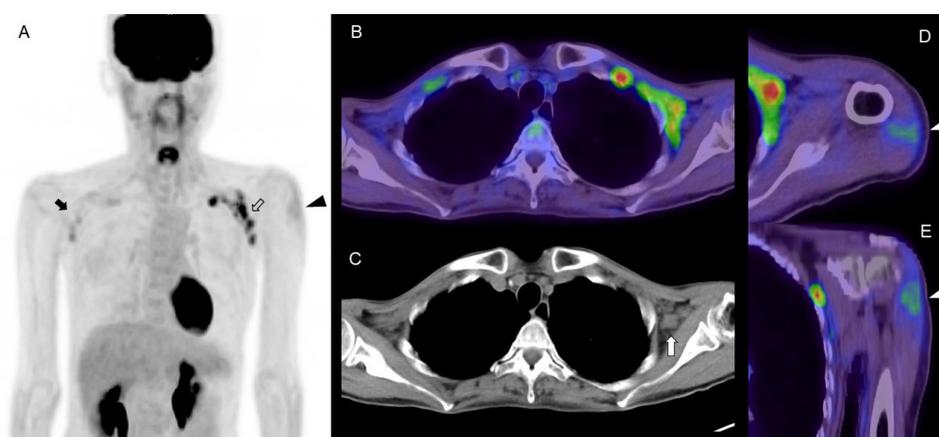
FDG PET/CT images in a woman in her 50s with abdominal malignancy at 4 days after COVID-19 vaccination. (A) MIP image, (B) axial fusion image, (C) CT image, (D) axial fusion image of deltoid muscle, (E) coronal fusion image of deltoid muscle. Increased FDG uptake is seen in the left axilla with supraclavicular lymphadenopathy (open arrow). There is slight FDG uptake in the right axillary and supraclavicular areas (arrow). The CT image shows enlarged lymph nodes with loss of fatty hilum in the left axillary and supraclavicular areas (white arrow). Intense FDG uptake in the left deltoid muscle indicates the site of COVID-19 vaccine injection (arrowhead). FDG uptake in the spleen was almost equal to that in the liver, which might have been caused by the vaccination.
